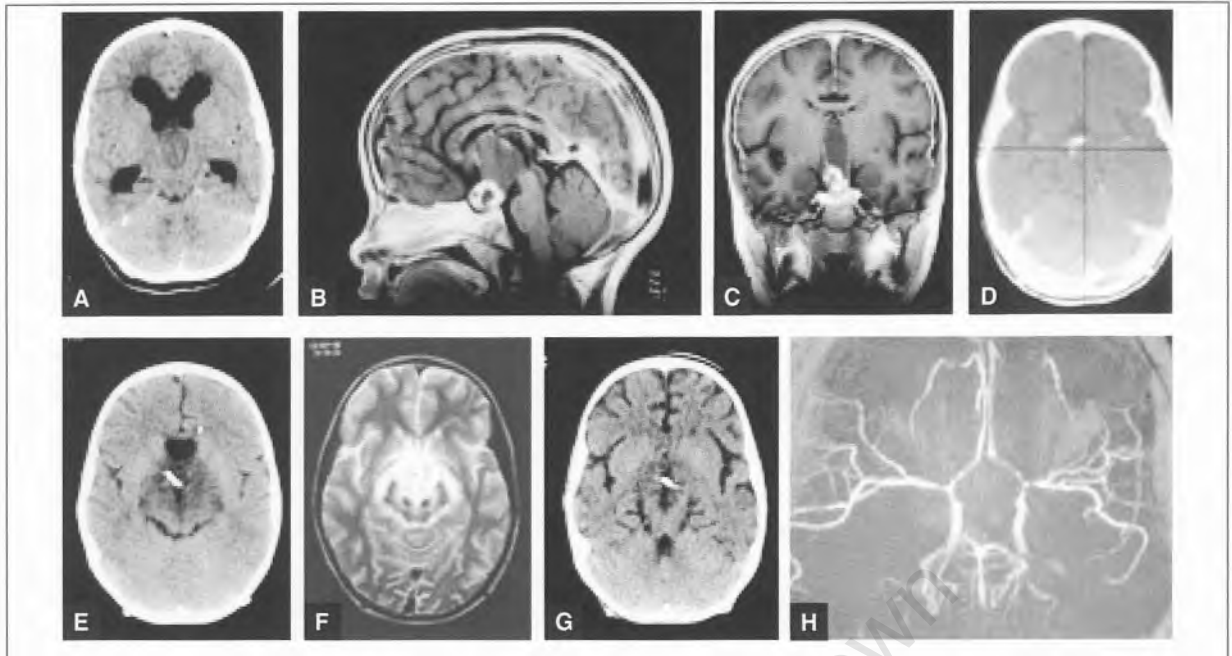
Axial CT at presentation (a), sagittal (b) and corona! (c) T1 weighted MRI with gadolinium following shunt insertion, showing the tumour cyst located within the third ventricle. Following the stereotactic planning scan (d), the catheter was implanted successfully in the cyst. Follow-up CT ten days following the last dose of bleomycin showing low density changes in the thalami and midbrain bilaterally (e). Axial T2 MRI 15 days after bleomycin showing extensive hyperintensities in the diencephalon (f) while CT scan 2 months later showed marked cerebral atrophy (g). MR angiogram at 9 months (h) showed diffuse narrowing of both middle cerebral arteries and anterior cerebral arteries bilaterally with a moya-moya blush.
